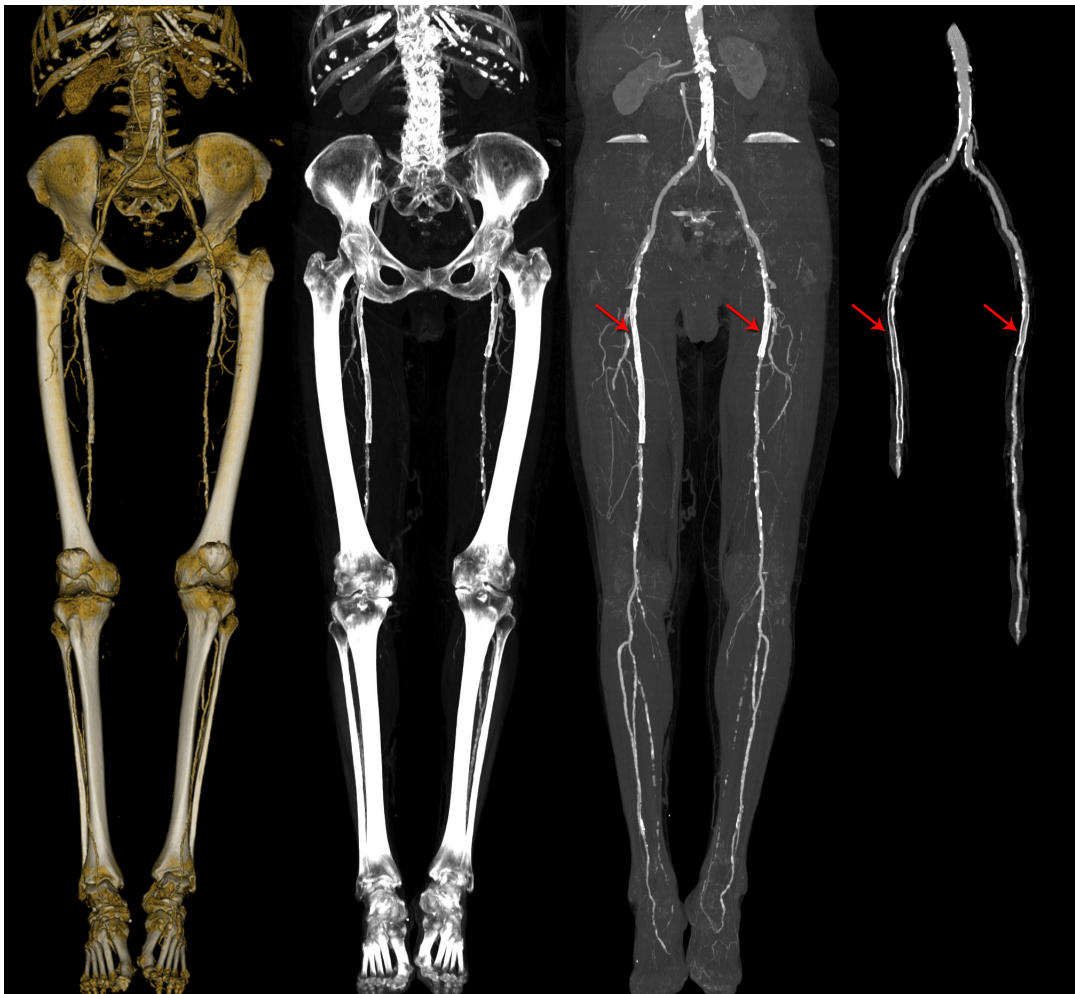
CTA* data-set of human body. From left to right, the first image displays *DVR* of the data-set, the second *MIP* with bones, the third *MIP* without bones and the right image presents the stents, indicated by the red arrows, with *CR* in order to show that they indeed allow the blood to flow through the vessels. (Images created using the *AngioVis* Toolbox)
